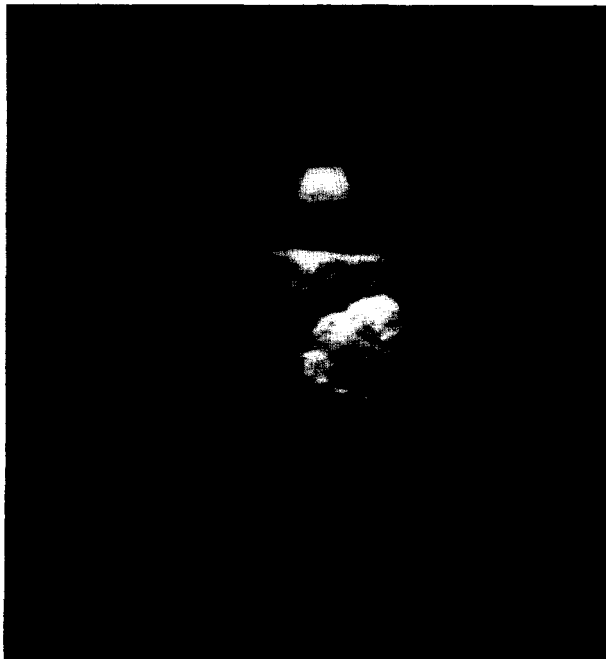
Sample ultrasound image of canine brain.
